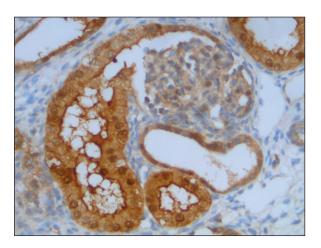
Strong diffuse cytoplasmic expression of ACBP in the distal tubule emerging from a developing nephron (*on the right*). The ACBP-reactive distal tubule is going to fuse with a collecting tubule (CT) originating from the ureteric bud. ACBP-positive globules are also evidenced inside the lumen of the distal tubule (original magnification ×40).
